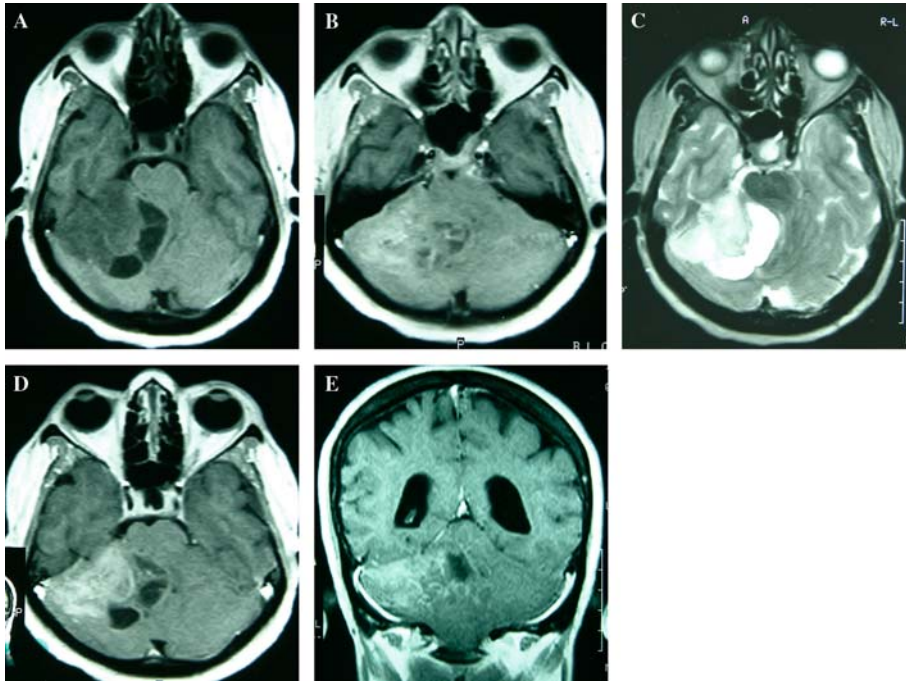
(A) Un-enhanced T1WI axial MR image shows right cerebellar intra-axial lesion with associated exophytic component in the ipsilateral CP angle cistern. The mass is hypo-intense compared to normal brain parenchyma. Posterior margin of the lesion is surrounded by CSF loculation. Mild rotation and displacement of the brainstem is also noted. (B) The solid component of the mass is iso-intense to hyper-intense on T2WI axial MR image along with CSF loculation that is homogeneously hyper-intense to normal parenchyma. Brainstem is displaced and distorted by the mass. (C) Post-contrast axial MR image. There is ill-defined and mild enhancement of the solid component of the mass. However, cystic component is not showing any enhancement. (D) Post-contrast MR image at higher level shows ill-defined mass with heterogeneous enhancement. Medial component of the lesion do not show clear demarcation of the interface between the tumor and brain parenchyma. (E) Coronal post-contrast MRI – the mass is predominantly intra parenchymal in location confined to right cerebellar hemisphere.
